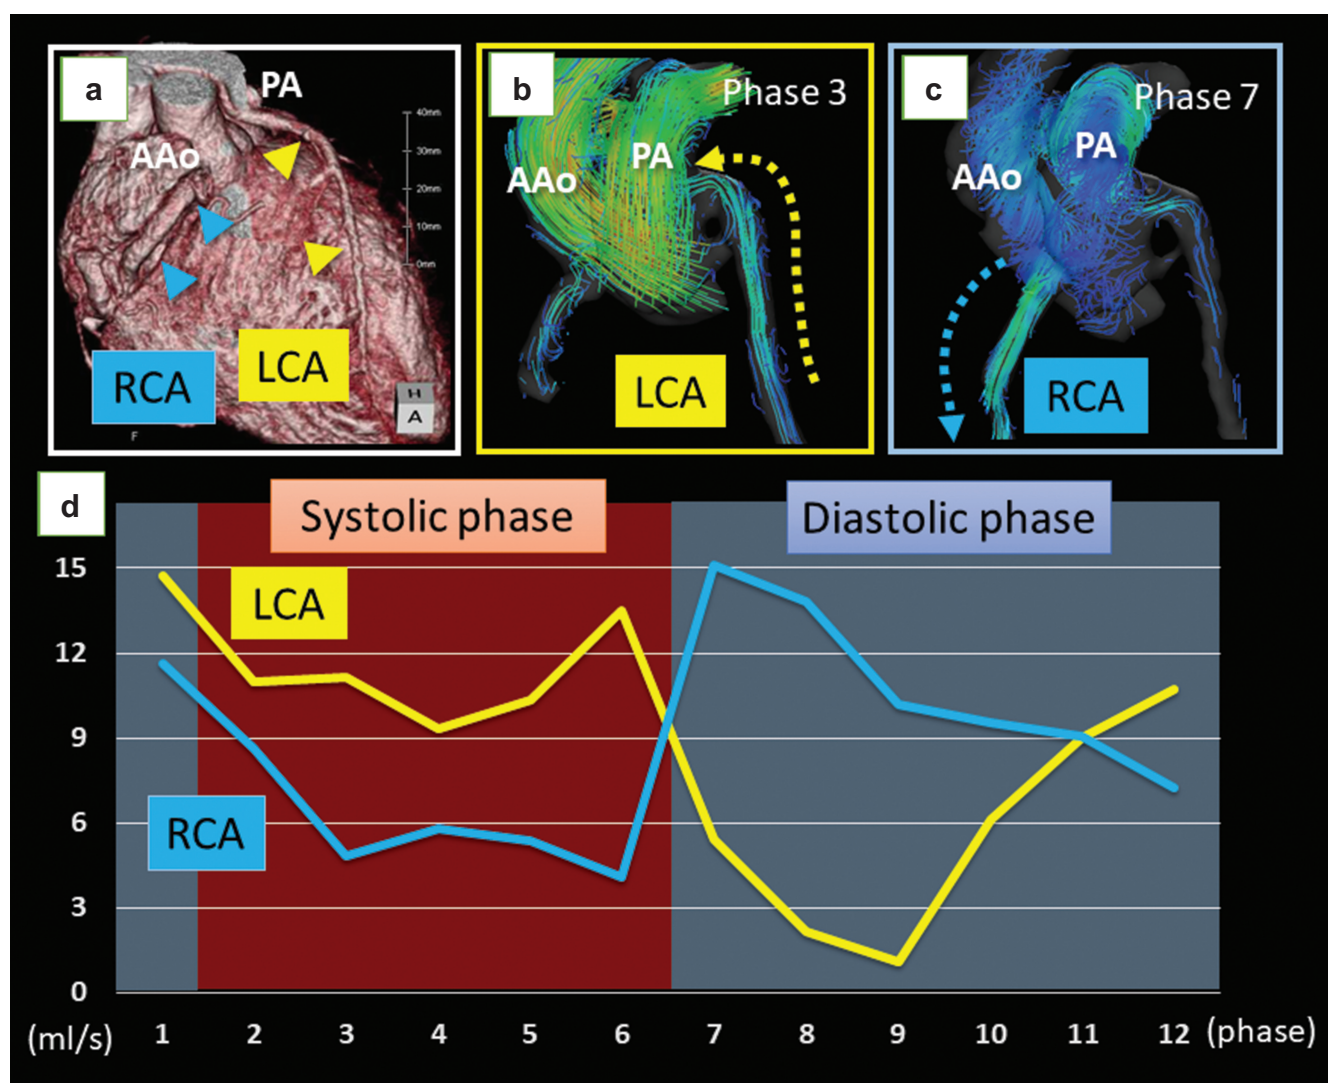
A case of Bland–White–Garland syndrome. (a) Computed tomography volume rendering image showing the RCA arising from the Valsalva sinus and the LCA arising from the PA (a). (b) and (c) 4D flow MRI clearly visualized the retrograde flow of the LCA (b) and the antegrade flow of the RCA (c) at different phases. (d) Quantitative assessments revealed that antegrade RCA flow was dominant in the diastolic phase, while retrograde LCA flow was dominant in the systolic phase. The flow volumes of both arteries were increased (LCA, 5.84 mL; RCA, 5.81 mL; stroke volume of the left ventricle, 61.7 mL), which suggested coronary steal phenomenon. AAo, ascending aorta; LCA, left coronary artery; PA, pulmonary artery; RCA, right coronary artery.
